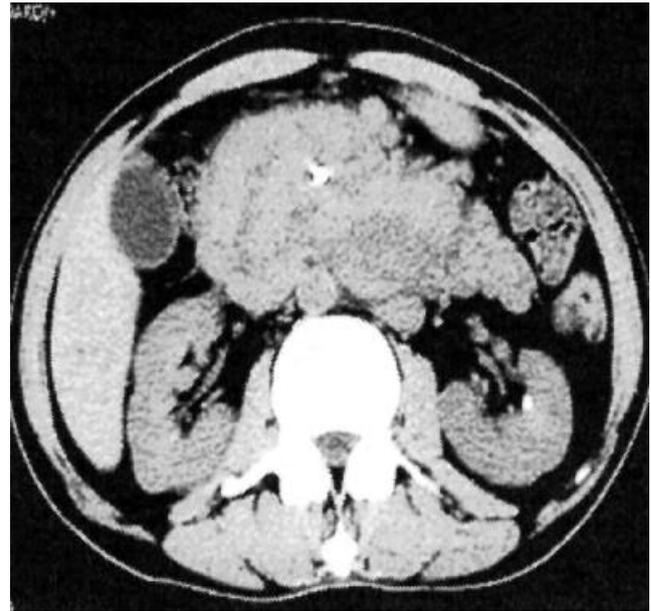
CT scan showing a large mass in the head of the pancreas with heterogeneous density and involvement of abdominal vessels.
